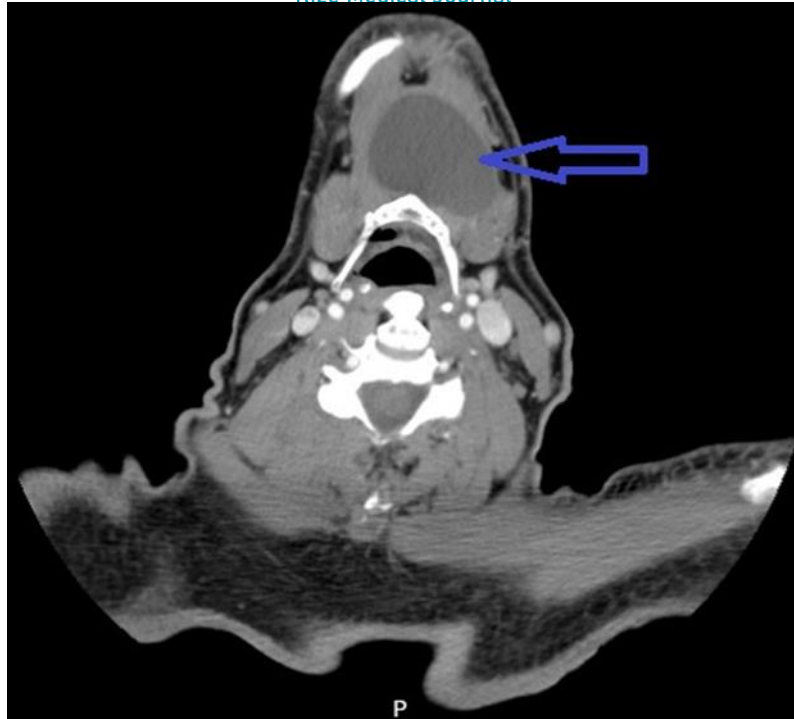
A contrast-enhanced neck CT shows a cystic mass extending to the anterior aspect of the hyoid bone in the axial plane (blue arrow).
